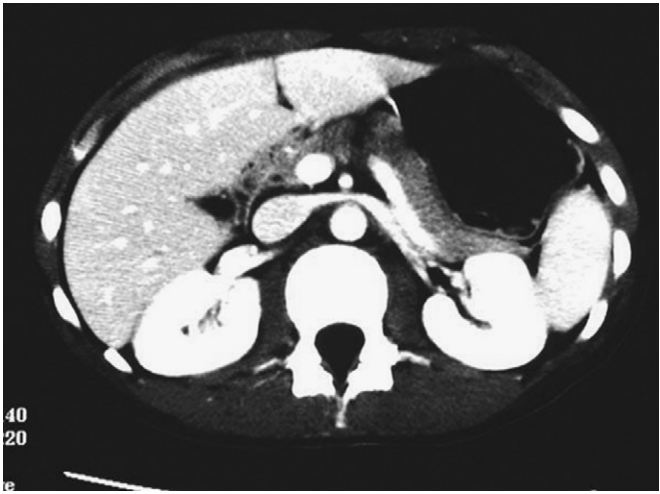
CT scan of patient with a grade III pancreatic laceration. (Courtesy Martin Eichelberger, MD, and Patrick McLaughlin, MD.)
